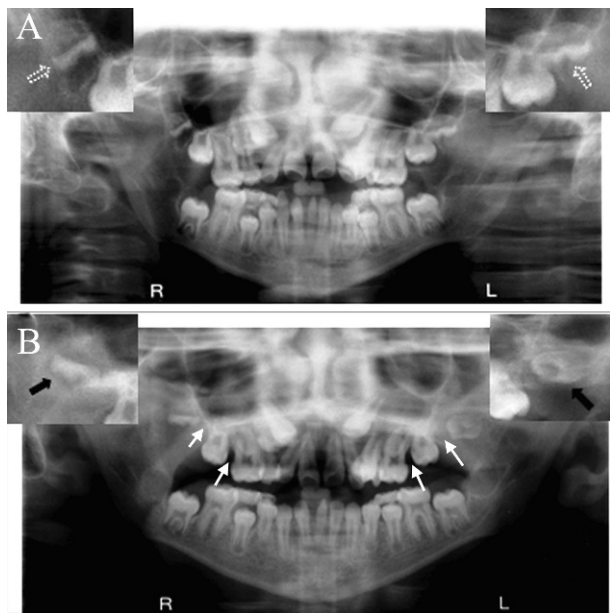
Panoramic radiographs of a patient in the late transitional dentition stage. A: Before distraction. B: After distraction. Note creation of space between the maxillary molars after distraction (white arrows). The extreme rotation of the maxillary third molars is also noted. Compare presurgical position (dotted arrows) to postoperative position (black arrows).
